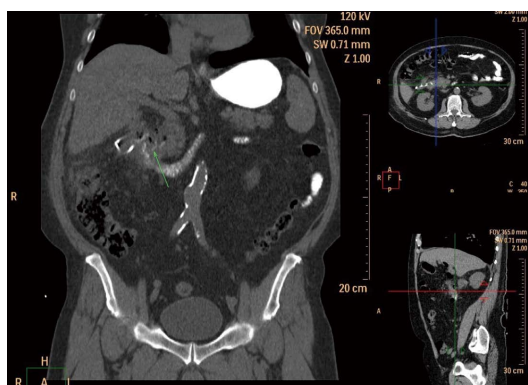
Computed tomography scan of the abdomen. Green arrow showing perforation site.
